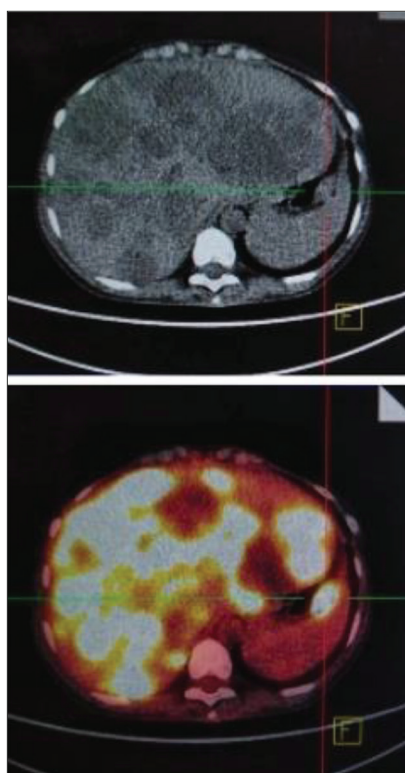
Axial CT, fused PET/CT images of the nodular lesion near the medial contour of the anterior part of the spleen with intense uptake of 18F-FDG
